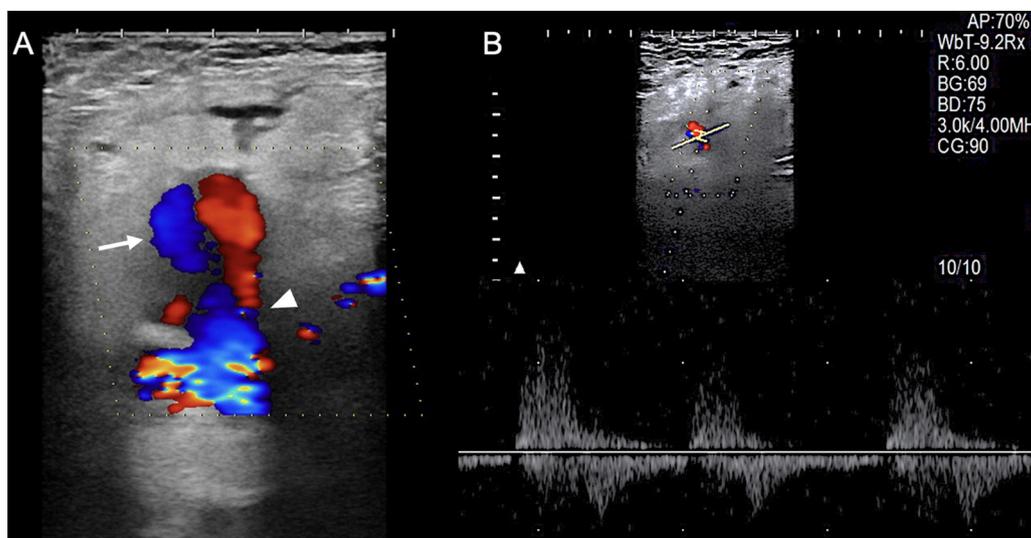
81-year-old man presenting with a pulsatile left inguinal tumour-like lesion at the puncture site with haematoma extending to the root of the thigh after transfemoral catheterisation eight days prior. Colour (A) and spectral (B) Doppler ultrasound images showing a pseudoaneurysm with turbulent flow and the "yin-yang" sign inside the sac (arrow) connecting to the left superficial femoral artery via a neck (arrowhead). Spectral Doppler reveals the bidirectional arterial flow characteristic of pseudoaneurysm.
